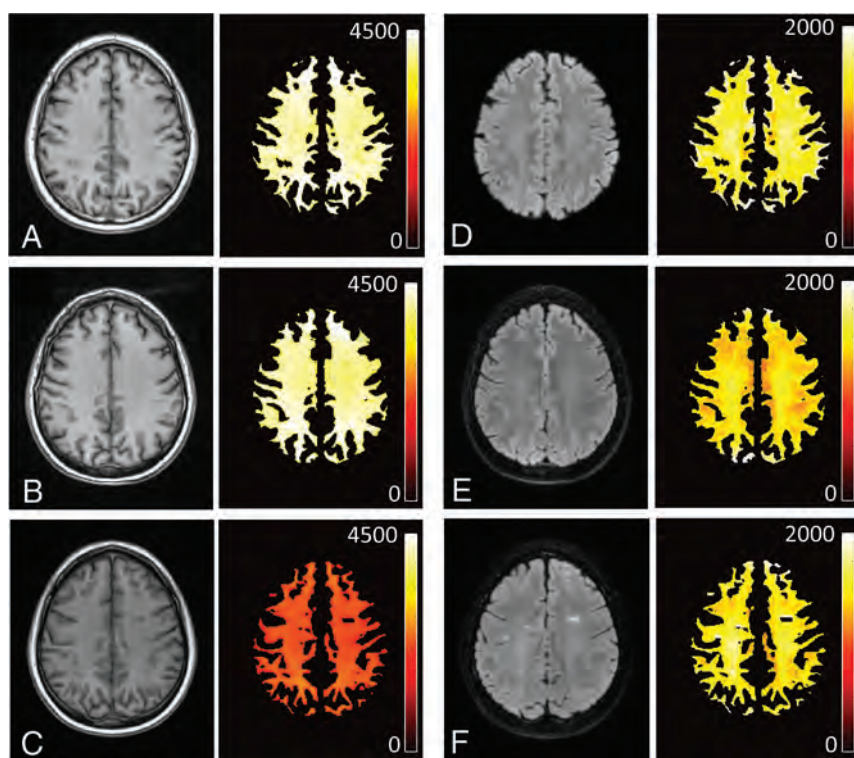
MPRAGE (A, B, and C, first column) and T2-FLAIR (D, E, and F, third column) images with their corresponding NAWM maps shown to the right of them (second and fourth columns, respectively) in a healthy volunteer (a 49-year-old man: A and D, upper row), a patient with MS with an EDSS score of 2 (a 56-year-old man: B and E, middle row), and a patient with MS with an EDSS score of 6 (a 46-year-old woman: C and F, lower row).
